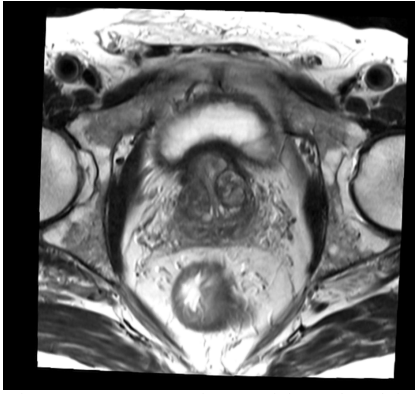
Transverse MR image of the male pelvis.
